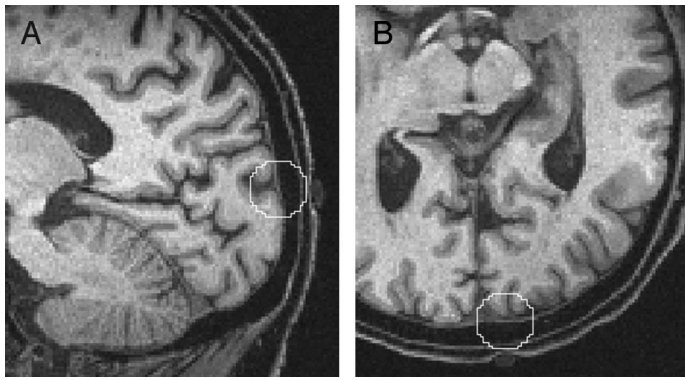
Location of the dorsomedial TMS site, marked with an oil capsule on the scalp in an anatomical MRI scan for subject AC, shown in sagittal (left) and axial (right) views. The 1-cm-diameter sphere under the capsule shows the area most strongly affected by TMS at this site.
